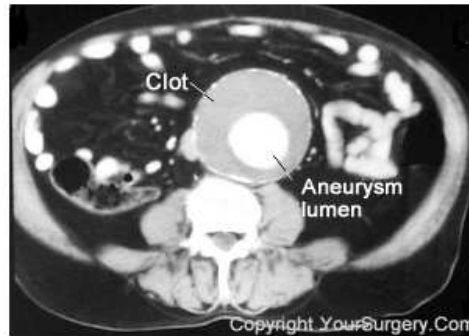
CT scan through an AAA revealing the presence of mural thrombus and size of the lumen (YourSurgery.com).
